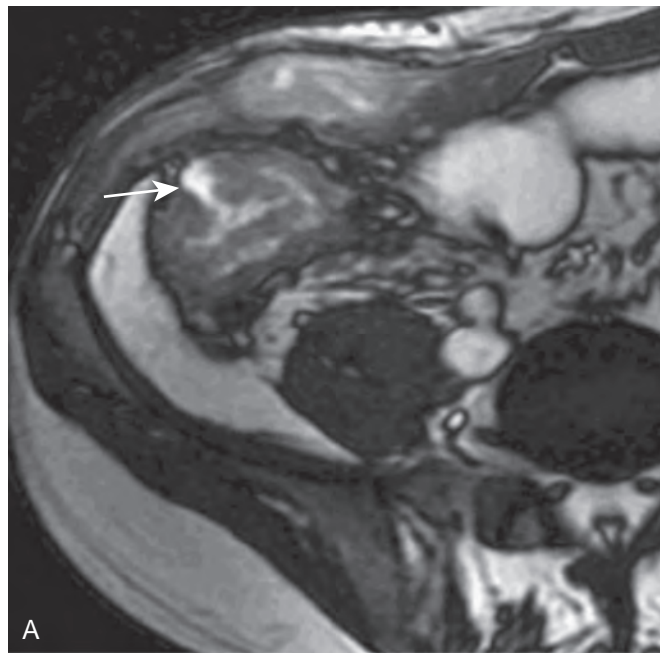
Deep ulceration. Axial (A) and coronal (B) true FISP MR images of the terminal ileum. Ulcers are visualized as thin lines of high signal intensity, longitudinally or transversely (fissure ulcers; arrows) oriented within the thickened bowel wall.
